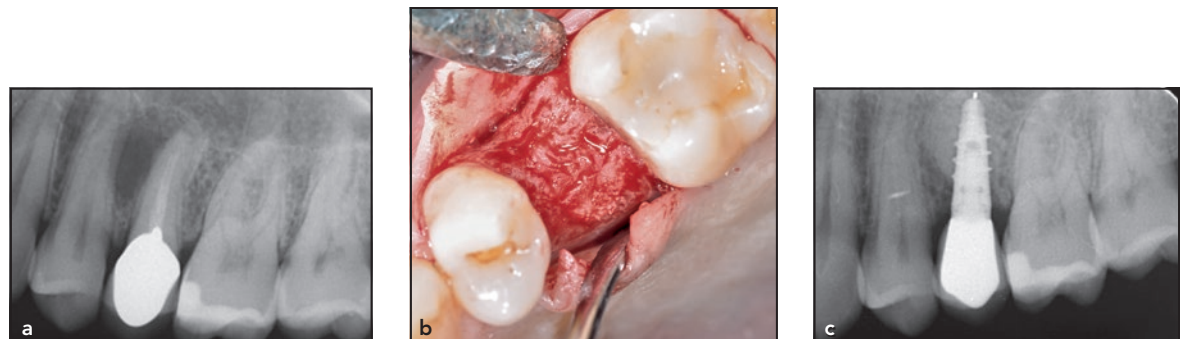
(a) A 49-year-old male patient presented with buccal swelling on maxillary left second premolar area. Radiographic examination revealed possible root fracture, and the tooth was scheduled for extraction and socket augmentation. (b) The extraction was grafted with BCP + collagen and allowed to heal for 6 months. Maintenance of good bone ridge and shape noted at the time of dental implant placement. (c) Radiograph taken at 1 year postloading revealed good bone support around the dental implant.
